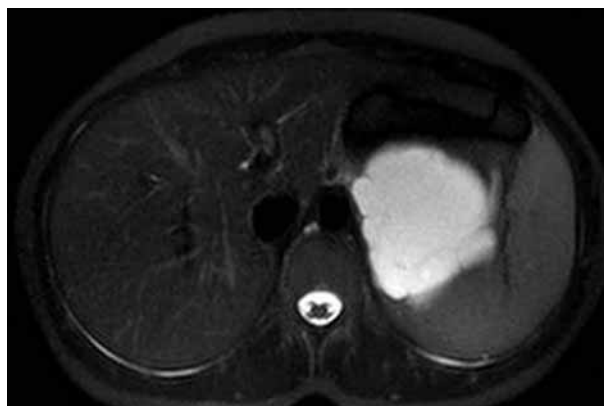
Abdominal MRI revealed a cystic lesion with many internal septa, independent of the left kidney and liver.
